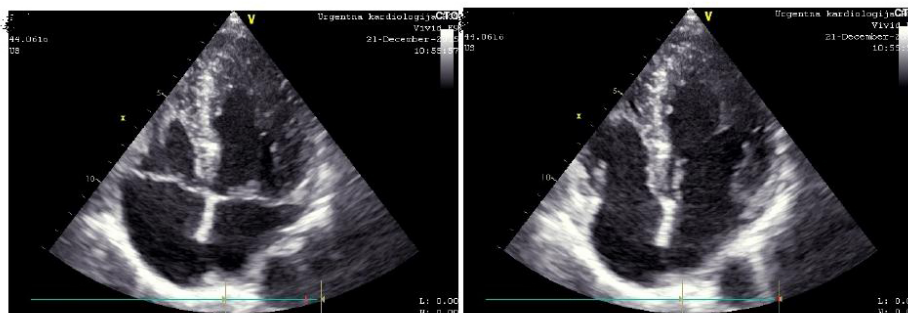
Apical 4-chamber view after 11 days of admission shows an improvement in left ventricular systolic function. A) Systole B) Diastole
